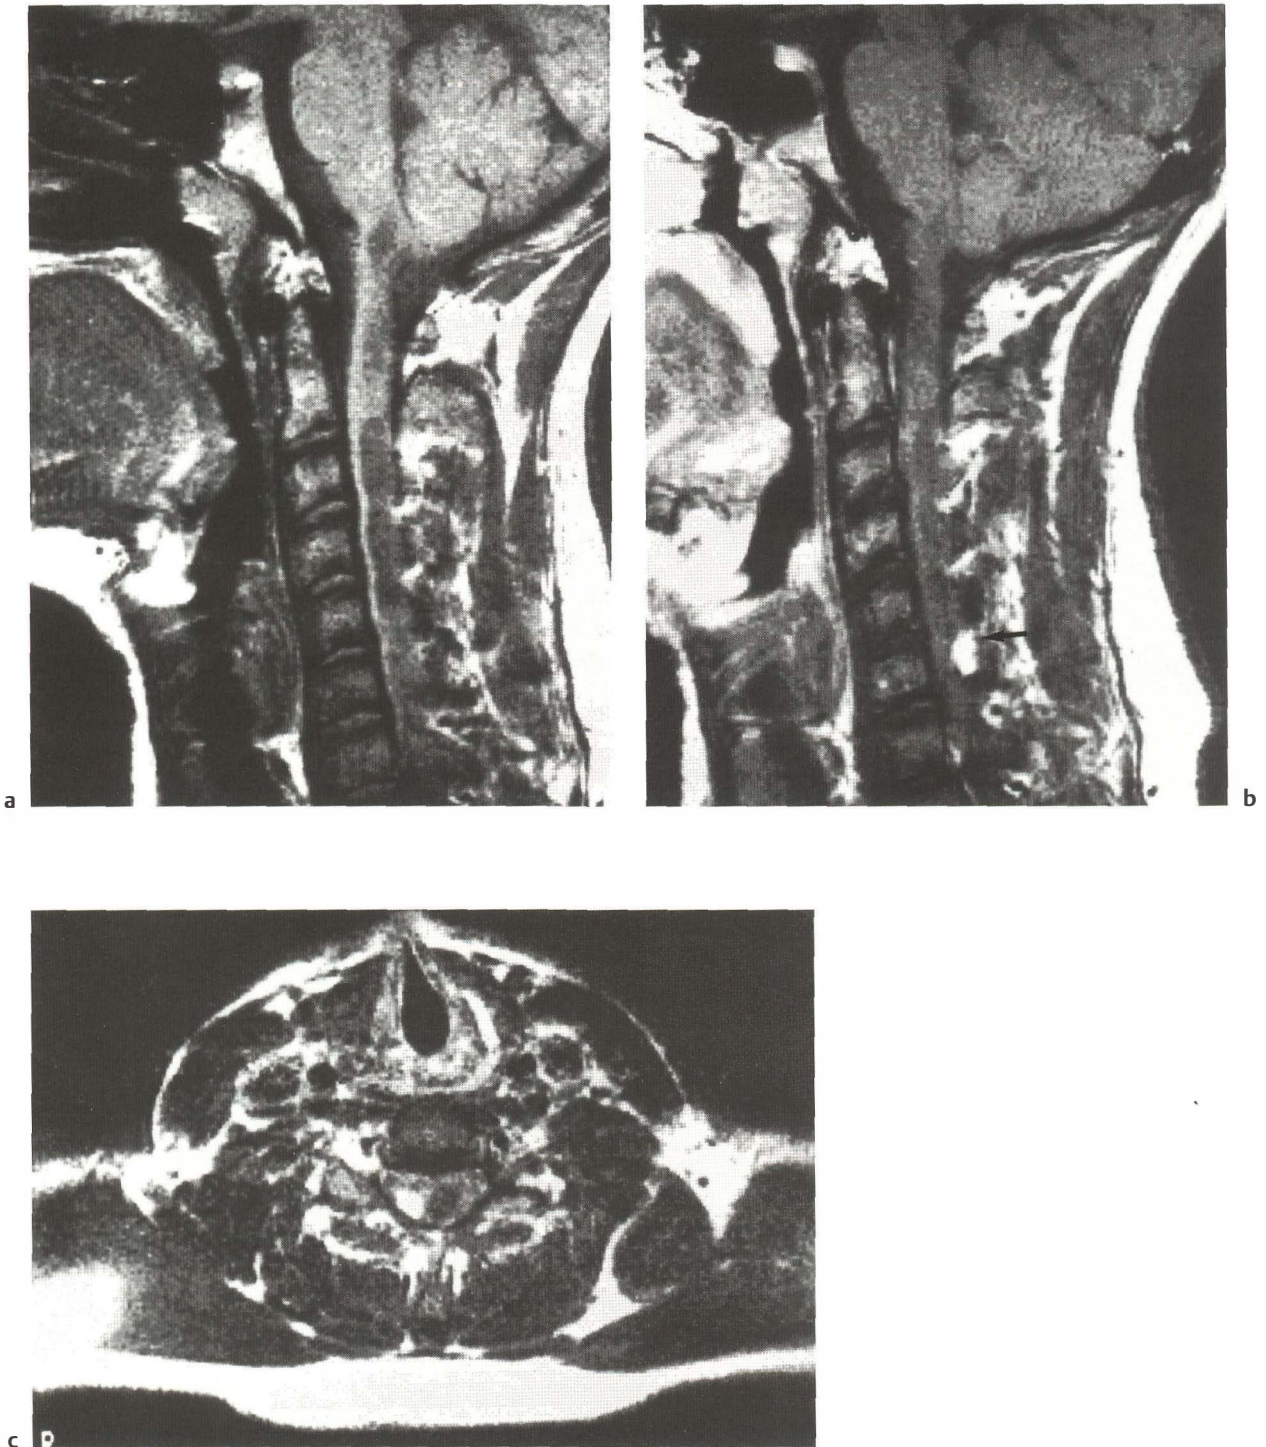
Hemangioblastoma (case 137). a Sagittal and b right parasagittal postcontrast T1-weighted images. There is cystic involvement of the entire spinal cord, associated with a small, intensely enhancing nodule located at the C6 level (arrow in b), eccentrically located on the right, as clearly shown on an axial contrast-enhanced T1-weighted image (c). d Post-operative MRI, showing disappearance of the cystic component both in this sagittal T1-weighted image and in an axial T1-weighted image (e)
